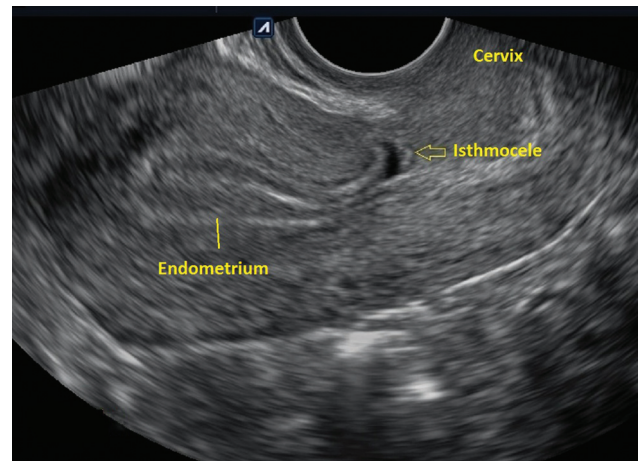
TVUS in the sagittal plane shows a triangular defect with a base communicating with the endometrial cavity. Assessment of the CSD is recommended after 3 months of a CS, particularly during the mid-follicular phase when fluid is present in the uterine cavity.⁷ CS, cesarean section; CSD, cesarean scar defect; TVUS, transvaginal ultrasound.
